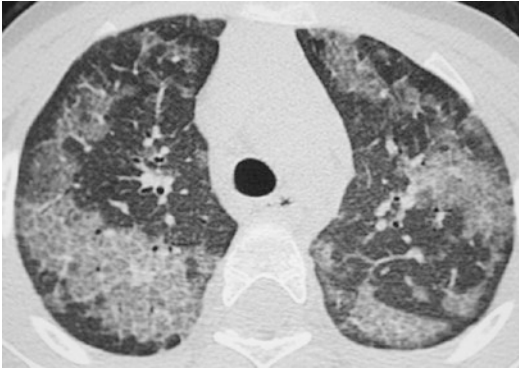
Alveolar proteinosis (AP) in 40-year-old man with myelogenous leucemia presenting with cough and dyspnea. Axial CT image displays bilateral geographical areas of ground-glass opacity. Interlobular septa are thickened and within these areas a fine reticular network of interlobular lines can be seen. These changes are referred to as the typical “crazy paving” appearance of AP
